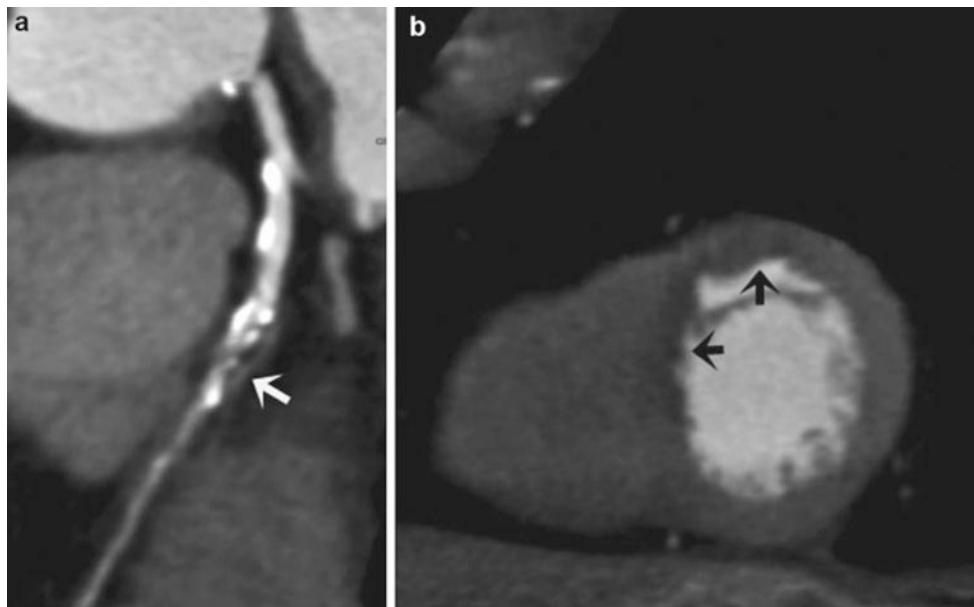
(a) In 69-year-old man with chest pain, negative initial cardiac biomarkers, and a nondiagnostic echocardiogram, coronary CT angiography (CTA) demonstrated a mixed plaque with calcified and noncalcified components in a high-grade stenosis (>70%) in the mid-left anterior descending coronary artery (arrow). (b) A rest perfusion
